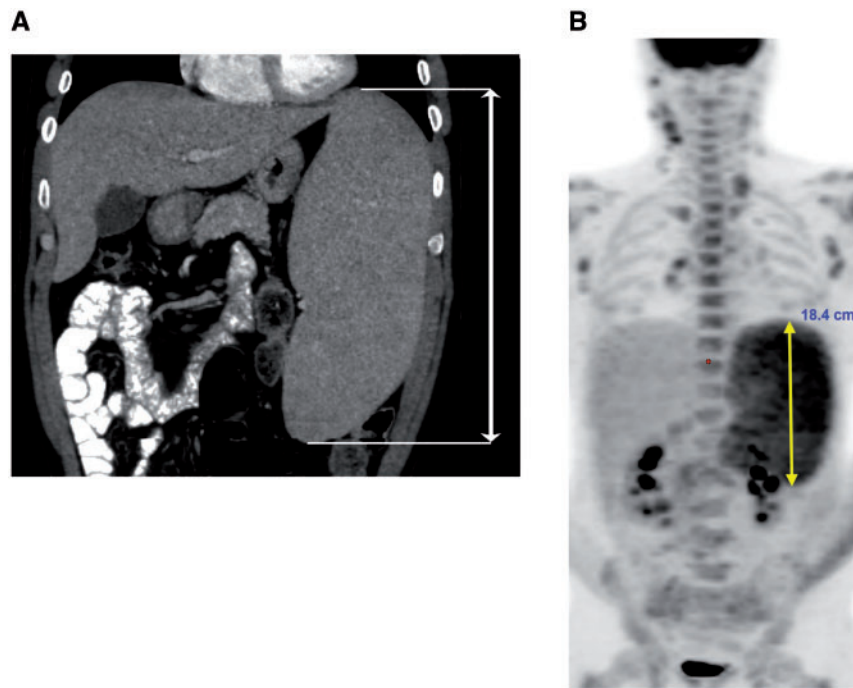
Recommendation for measuring spleen long diameter. (A) Coronal view of a computerized tomography (CT) scan image, (B) maximum intensity projection image of a positron emission tomography/CT.
